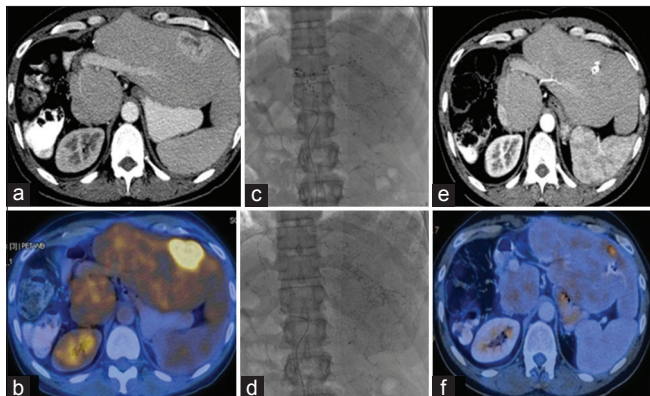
A 52 year old male patient with right hepatectomy status and hepatic metastases from gastrointestinal malignancy (colorectal malignancy). Contrast enhanced CT (a) showed a hypervascular lesion in left lobe of liver with significant activity on PET scan (b). Patient underwent TARE with ¹³¹I-Lipiodol (c, d). Follow up scan demonstrates lipiodol deposition after TARE with ¹³¹I-Lipiodol within the hyper vascular lesion and reduction in size and enhancement of lesions (e) with significantly reduced PET activity (f)
